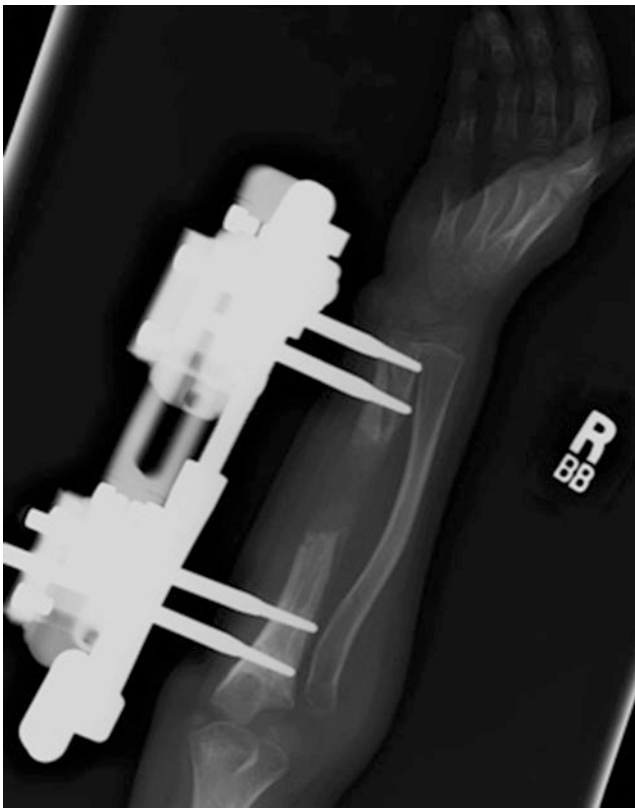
Case 2. X-ray 8 weeks after stage one surgery. As the ulna was lengthened, the entire radius was transported distally through the interosseous membrane. Note, however, the radial head remains dislocated
